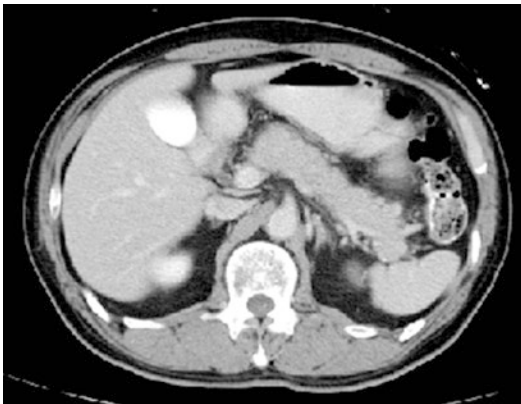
Abdominal CT shows diffuse enlargement of the pancreas with delayed enhancement in association with a capsule-like low-density rim
